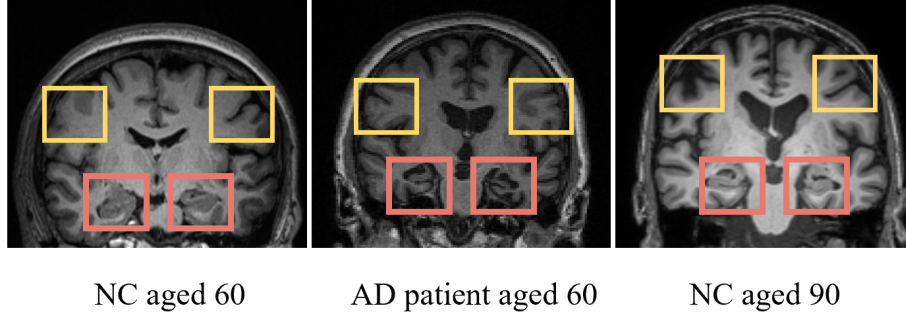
Comparisons of representative T1w MR images (hippocampi in red boxes, and peripheral brain sulci in yellow boxes) from 60-year-old NC and AD subjects, as well as a 90-year-old NC subject.
